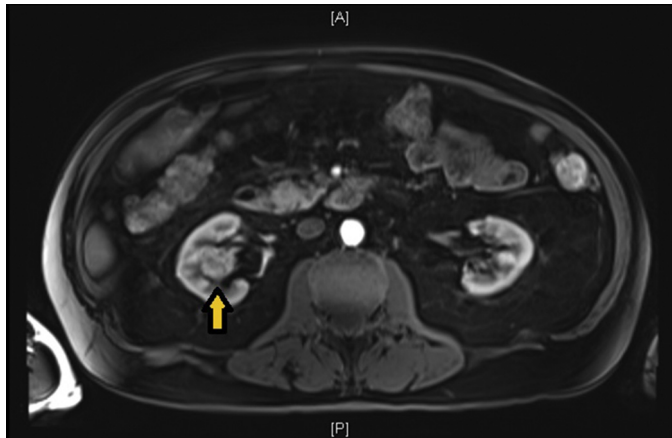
Preoperative MRI Abdomen and Pelvis with contrast. Right sided central renal mass seen in the axial view.
